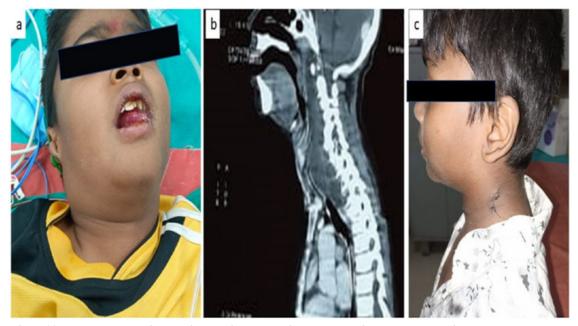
11 years old male child previously diagnosed with tuberculosis who was on anti tubercular treatment presented with neck swelling, stridor and new onset of fever. (a) Note the neck swelling; (b) CT scan showing large multi loculated cystic density of 12*1.67.2cm vol 71cc seen involving midline prevertebral, retropharyngeal region of neck from C2 to D4 causing compression of anterior structures ; (c) Post operative scar picture of external cervical approach to drain the pus.
